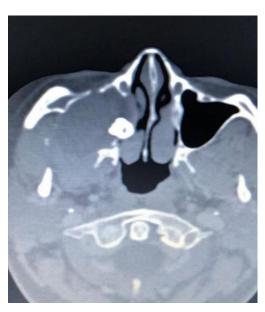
CT scan of the paranasal sinuses showed a well-defined solitary expansile right maxillary cystic mass measured 5.5x5x3 cm with scalloped thin bony margins that completely eroding the antero-lateral maxilla, with a crown of a tooth projecting inside the cystic cavity. The cyst displaced the right maxillary sinus wall laterally.
